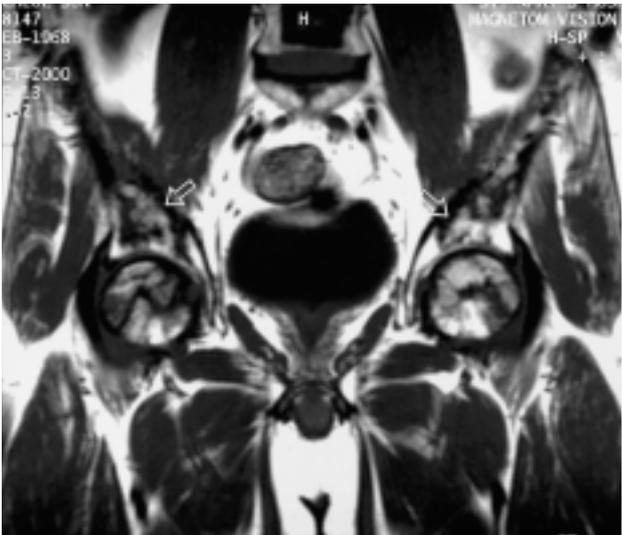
A thirty-two-year old male with acute myelocytic leukemia received allogeneic marrow transplant 16months ago and steroid pulse therapy was done immediately after the trasnplantation because of acute graft versus host disease. Coronal T1-weighted pre-contrast (A), post-contrast (B) and T2-weighted images (C) of the hip show large irregular defects in both femoral heads anterosuperiorly. In addition to osteonecrosis in both femoral heads, there are multiple medullary infarcts in both iliums (hollow arrows), sacrum (white arrows), and femoral diaphyses (black arrows).
